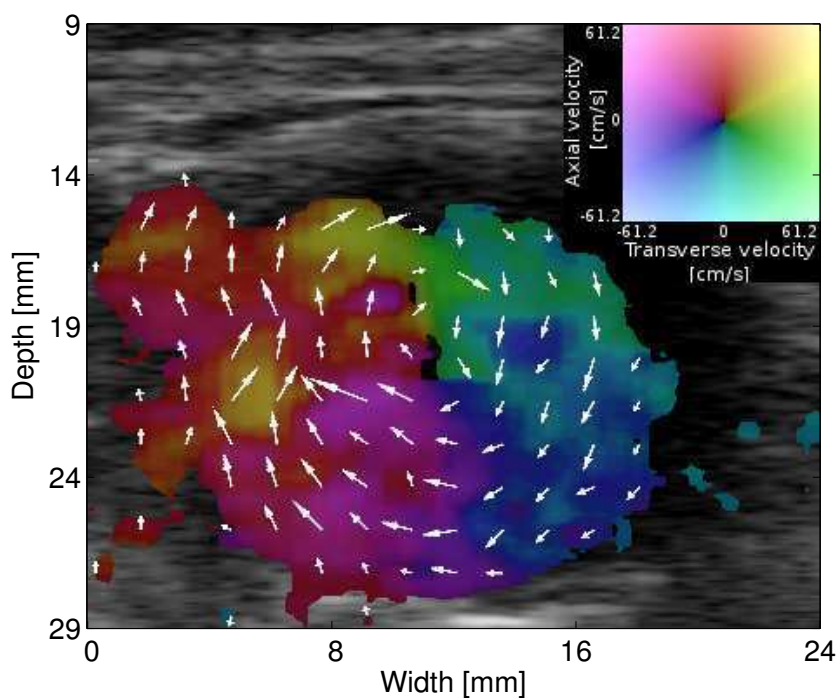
Real-time, in vivo vector flow ultrasound image of the abdominal aorta in the cross-sectional plane. The vector velocity color map is shown in the upper right corner.*
